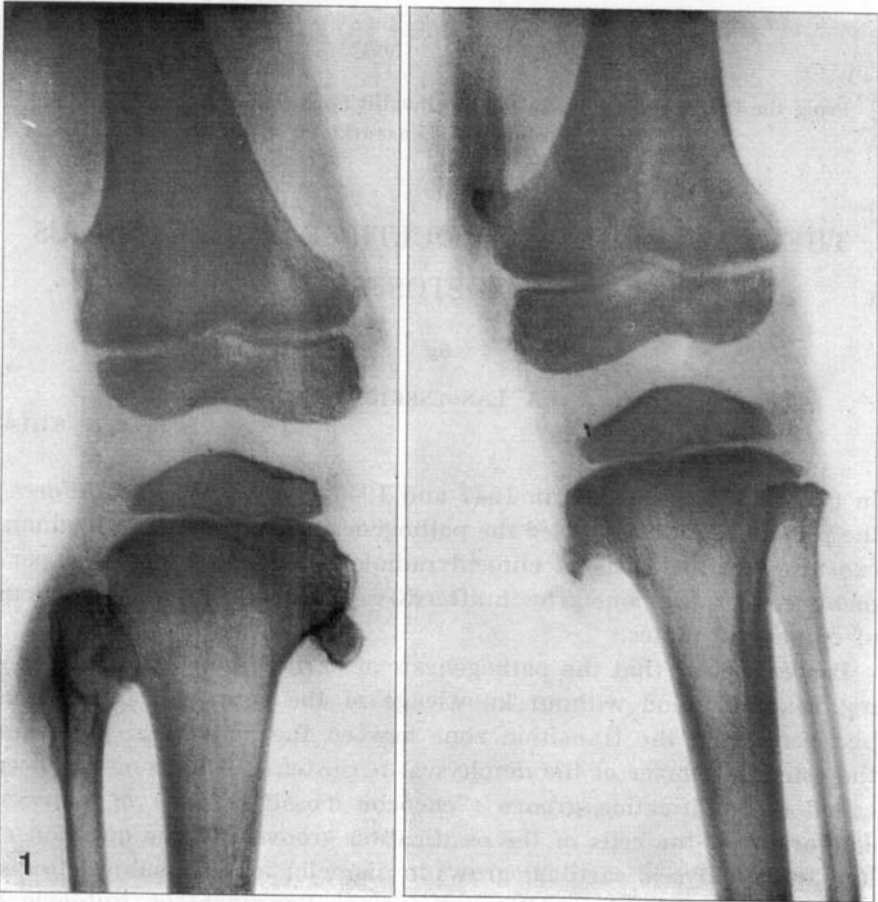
Radiograph of the knees of a child with multiple cartilaginous exostoses. Age four years.
